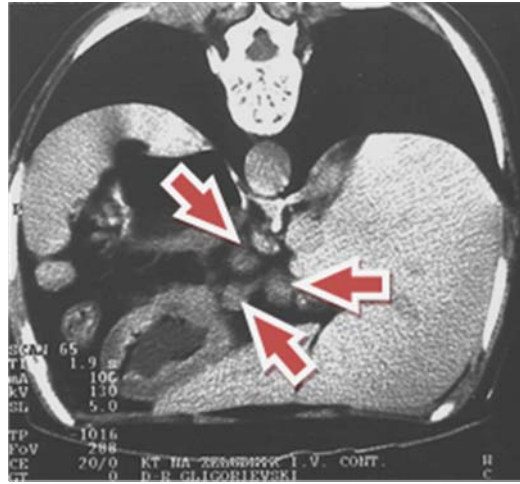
High-grade MALT lymphoma of the stomach: Axial contrast-enhanced CT scan obtained through the stomach shows diffuse wall thickening of the body, with minimal contrast enhancement. MS deposits in lymph nodes
